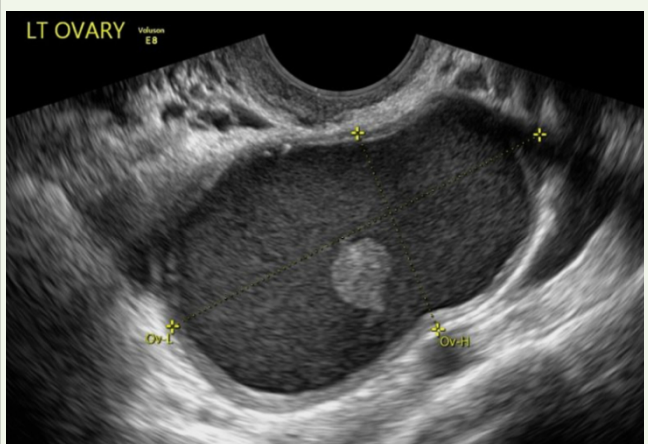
Diffuse low-level internal echoes giving a “ground-glass” appearance with an echogenic solid component, a classic sonographic feature of an endometrioma.
